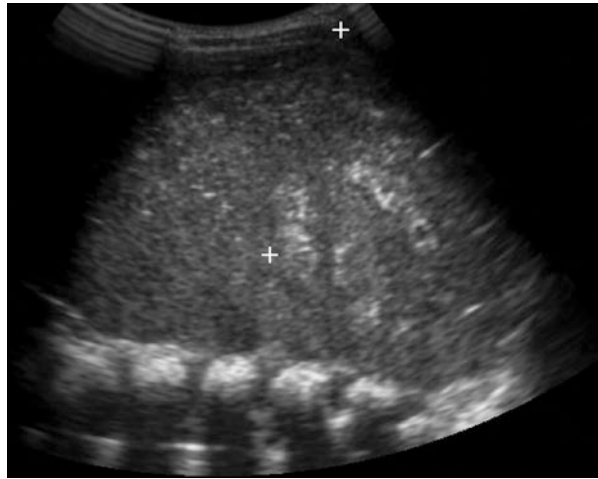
Ultrasound image taken as the biopsy needle (arrows) is deployed
